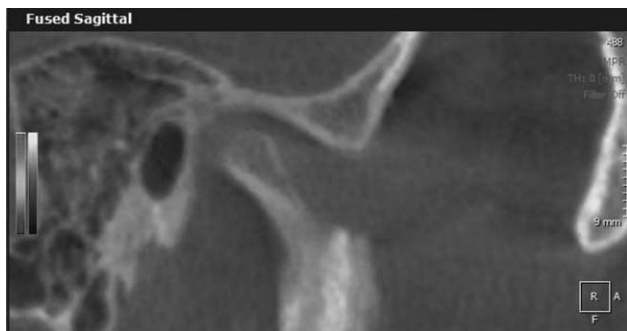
Cone beam computed tomography image after superimposition of condyle (red and yellow) based on the anterior cranial base using On-Demand 3D.
